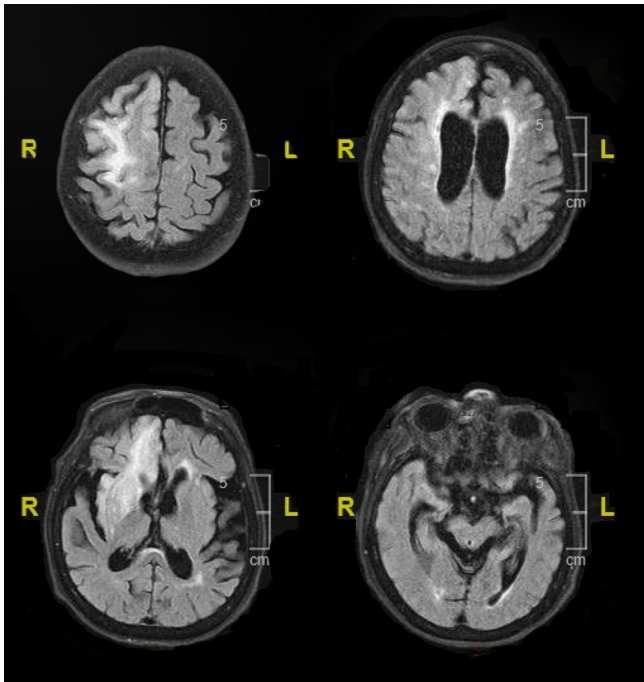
MRI performed on post-thrombectomy day 1. Axial FLAIR images demonstrate a small area of cytotoxic edema within the right frontal lobe, basal ganglia and insula consistent with recent infarction. However, much of the territory at risk identified on preoperative CTP appears normal.
